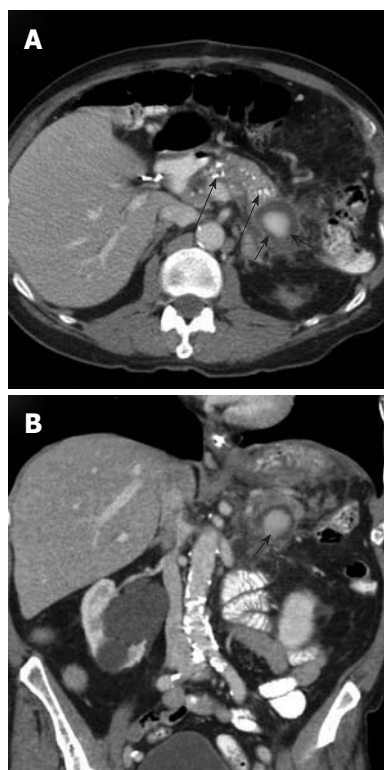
Upper gastrointestinal hemorrhage from pancreatitis related pseudoaneurysm. A: Axial contrast-enhanced computed tomography (CECT) scan, obtained in a patient who presented with hematemesis, shows pancreatic calcifications (long black arrows) indicating chronic pancreatitis and an enhancing mass (black arrows) in the pancreatic tail; B: Coronal CECT shows the rounded enhancing mass (black arrow) with surrounding inflammatory changes. This is suspicious for a pancreatitis-related pseudoaneurysm as the source of the upper gastrointestinal hemorrhage.
